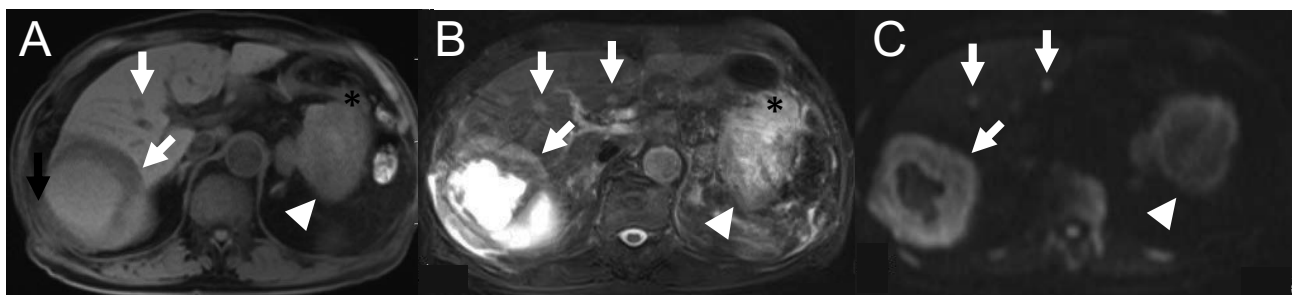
Abdominal magnetic resonance imaging (MRI) showed a pancreatic mass (white arrowhead) with internal heterogeneity, appearing iso-intense on T1-weighted images (A), hyper-intense on T2 fat-suppressed images (B), and low-intense with peripheral hyperintensity on diffusion-weighted images (C). It was in contact with enlarged lymph nodes and contiguous with the posterior wall of the upper gastric body (*) (A, B). Metastatic liver tumors (white arrow) were noted throughout the liver, appearing as low signal intensity on T1-weighted images (A), and high signal intensity on T2 fat-suppressed images (B) and diffusion-weighted images (C). The interior of an 8 cm tumor in the right hepatic lobe showed iso-signal intensity on T1-weighted images (A), and high-signal intensity on T2 fat-suppressed images (B), suggesting the presence of a liquid component. Furthermore, an irregularly shaped mass (black arrow) was noted within the abdominal cavity (A), showing peritoneal metastasis.
